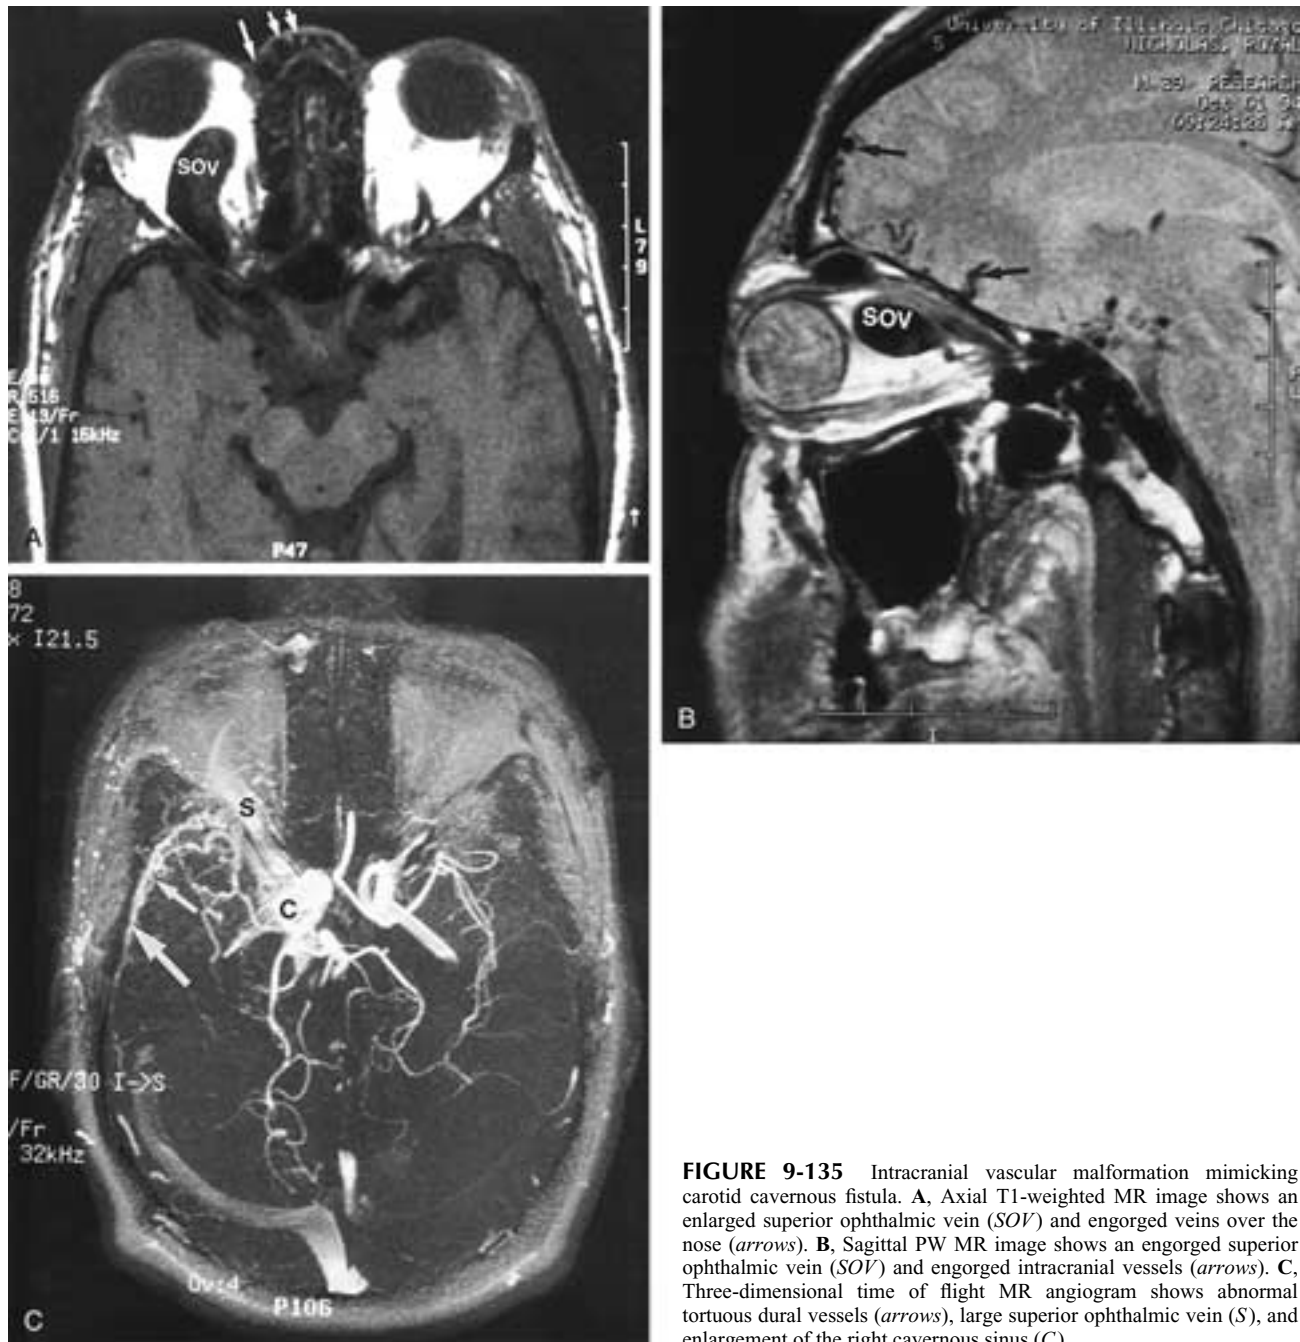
Intracranial vascular malformation mimicking carotid cavernous fistula. A, Axial T1-weighted MR image shows an enlarged superior ophthalmic vein (SOV) and engorged veins over the nose (arrows). B, Sagittal PW MR image shows an engorged superior ophthalmic vein (SOV) and engorged intracranial vessels (arrows). C, Three-dimensional time of flight MR angiogram shows abnormal tortuous dural vessels (arrows), large superior ophthalmic vein (S), and enlargement of the right cavernous sinus (C).
